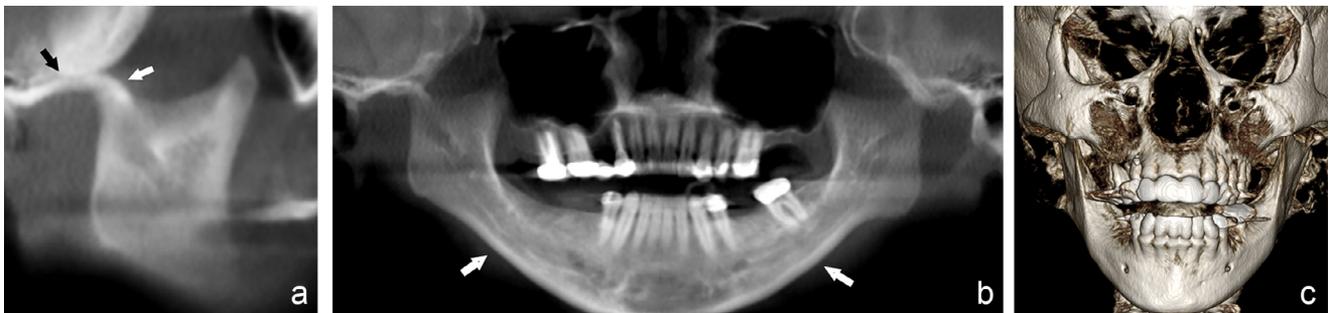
CBCT reformations show some of classic features of JIA: (a) Sagittal oblique view of the right side of the mandible shows a condylar stump (white arrow) that is positioned anterior to the eminence. The fossa and eminence are not developed (black arrow) as this condition most likely occurred earlier in life before their development. The corionoid process appears long in comparison to the condylar process, (b) Panoramic reformat shows steep mandibular planes (arrows) and very short mandibular rami, (c) 3D surface rendering shows an anterior open bite has occurred due to the posterior rotation of the mandible. The oropharyngeal airway is often compromised due to this posterior rotation due to posterior displacement of the tongue (Courtesy, M. Noujeim DDS, MS).
